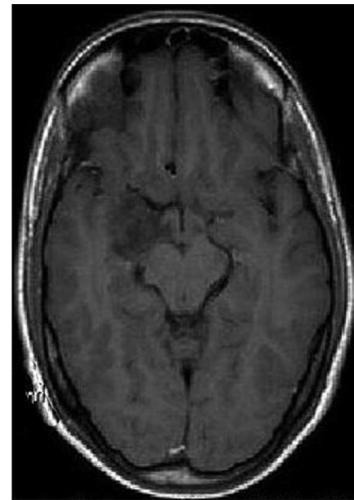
The MRI of the brain showing a cortical-based mass lesion at the medial aspect of the right temporal lobe, involving the Amygdala and part of the head of the hippocampus
